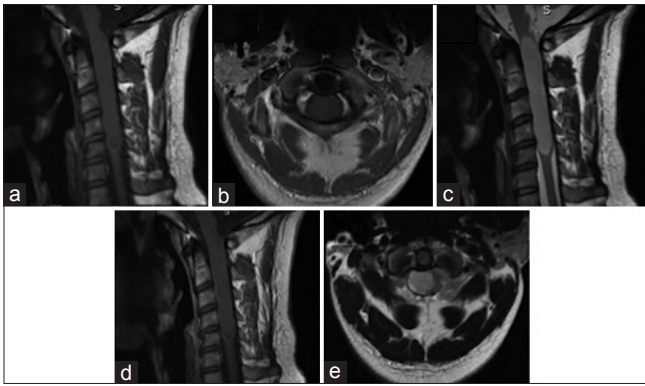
The typical radiological findings in spinal subependymoma. A well-defined eccentrically placed, intramedullary lesion can be seen extending from cervicomedullary junction to C5 causing distinctive steep dilation of spinal cord: Bamboo leaf sign. Lesion is iso to hypointense on T1-weighted images (a and b) and hyperintense on T2-weighted image. There is no evidence of perilesional edema or syrinx formation (c). No significant enhancement is seen on T1-weighted postcontrast image (d and e)
